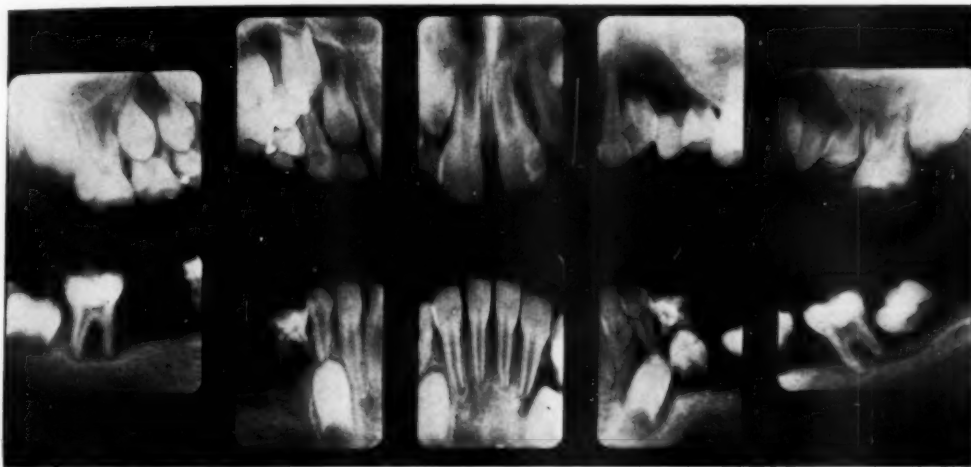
Hand-Schüller-Christian disease in a boy of eight years. Roentgenogram revealing destruction of the alveolar process in the right maxilla and posterior regions of the mandible. The teeth in the involved regions are being exfoliated, including some which have only partially developed. (Reproduced, with permission, from Stafne, E. C.: *Dental Roentgenologic Aspects of Systemic Disease*. J. Am. Dent. A. 40: 265-283, March 1950.)
